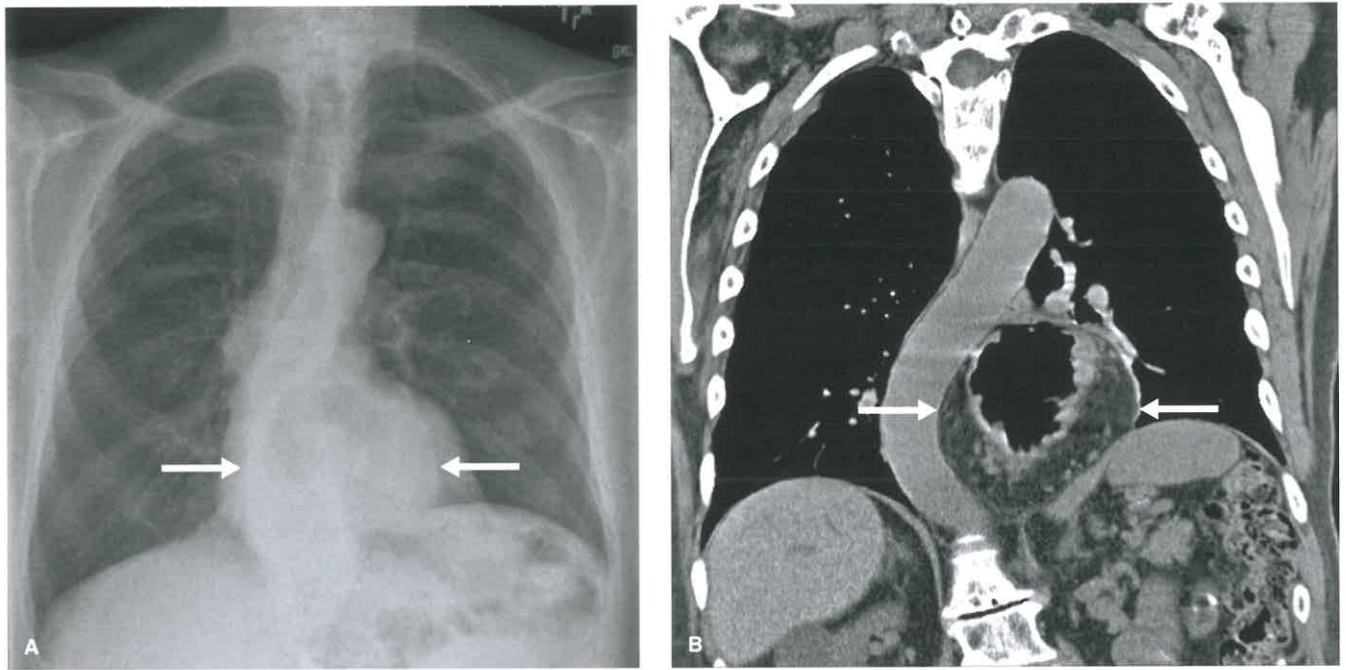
Hiatal Hernia. A: Chest radiograph shows a retrocardiac mass containing air (arrows). B: Coronal CT scan at the level of the descending aorta shows a hiatal hernia (arrows).
